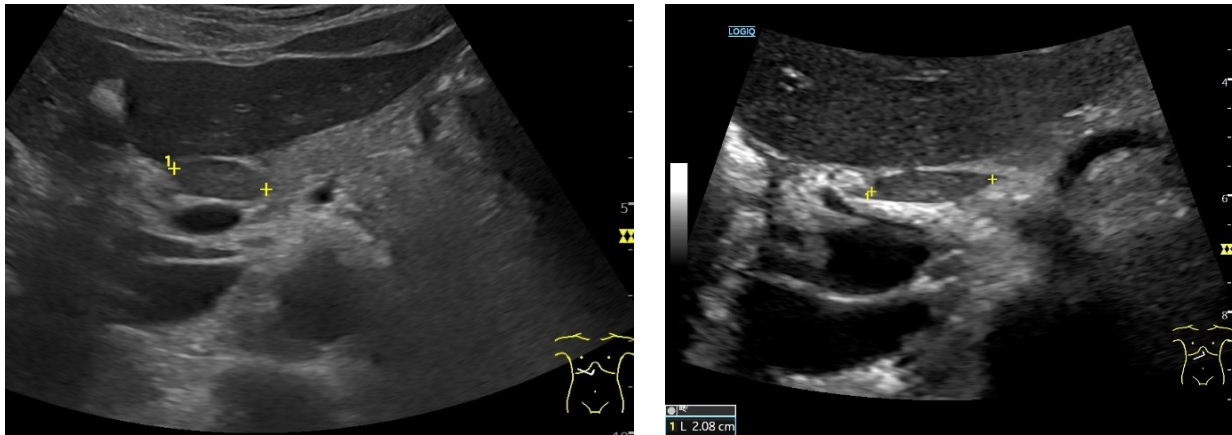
A-B. Ultrasound Imaging of a Hepatic Hilum Lymph Node:
